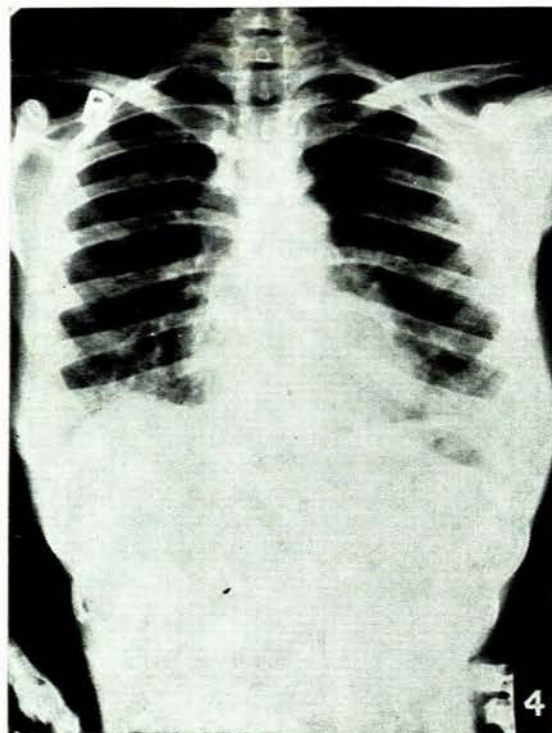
Final X-ray of chest on 2 March 1961 taken 3 days after the follow-up pulmonary-function study and 7 weeks after commencement of steroid therapy — case 4.
